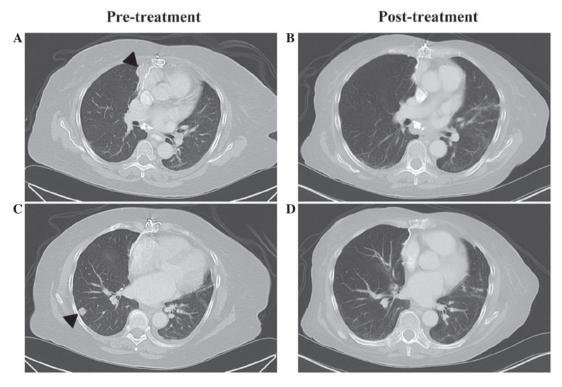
Representative axial computed tomography images of recurrent thymoma (A and C) prior to and (B and D) following treatment. Complete disappearance of (A) a right paracardiac mass and (C) a right lung nodule (indicated by arrowheads) was observed after six cycles of systemic antitumor therapy.
